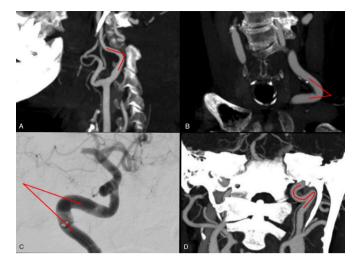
CT angiography maximum intensity projections (A, B, D) and DSA right ICA injection (C) showing examples of vascular tortuosity grades (indicated in red). (A) Sagittal view of 60°–90° ICA turn. (B) 30°–60° CCA turn. (C) <30° ICA turn. (D) ICA loop. CCA, common carotid artery. DSA, digital subtraction angiography; ICA, internal carotid artery.
